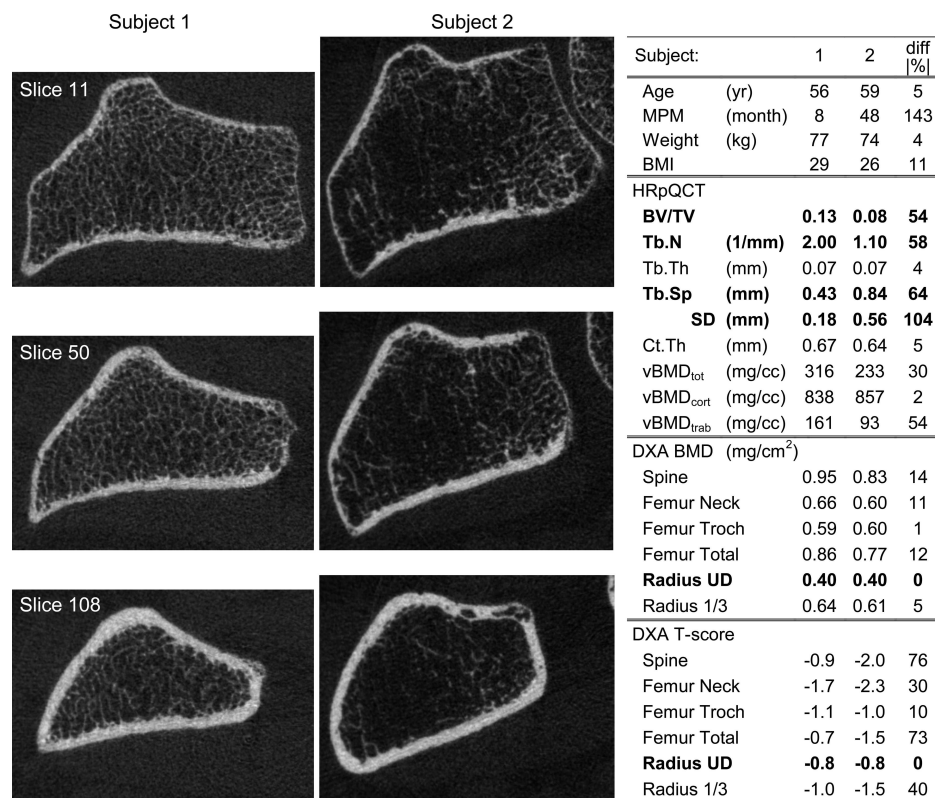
HR-pQCT images of the radii of two subjects with identical ultradistal radius areal BMD values and T-scores (UD radius BMD = 0.40; T-score = -0.8). Slice 11 (top row) is most distal, and slice 108 (bottom row) is most proximal. Trabecular structure appears well maintained and interconnected in subject 1, whereas trabeculae are scarce and not well interconnected in subject 2. Subject data and results of HR-pQCT, MRI, and DXA analyses for these subjects are tabulated above. HR-pQCT data show that the trabecular parameters BV/TV, Tb.N, Tb.Th, and Tb.Sp SD (a measure of structural heterogeneity) differ by ~50–100% between these subjects. These images and data clearly show that trabecular and cortical structure may differ in patients with identical areal BMD values.
